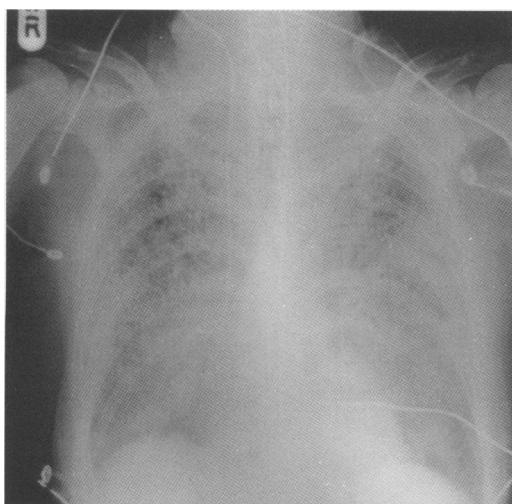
Chest radiograph showing diffuse alveolar shadowing consistent with severe pneumonitis.
